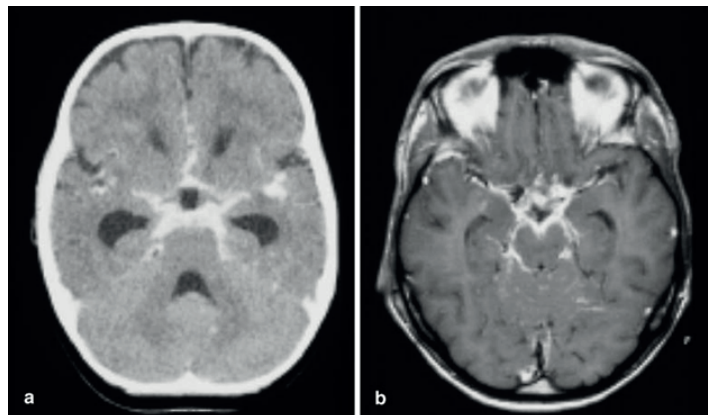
CT scan report TM patients
